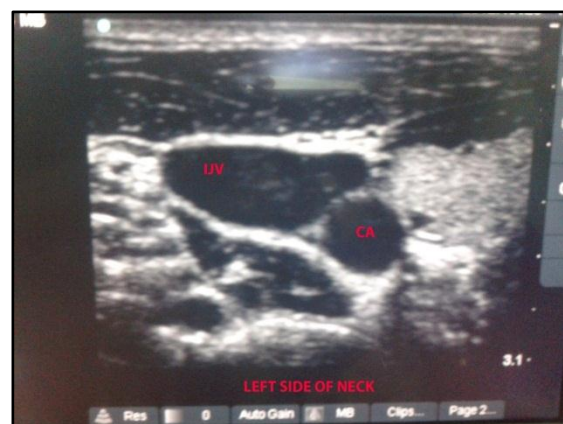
Anterolateral Position of IJV in Relation to CA on Ultrasound Screen
